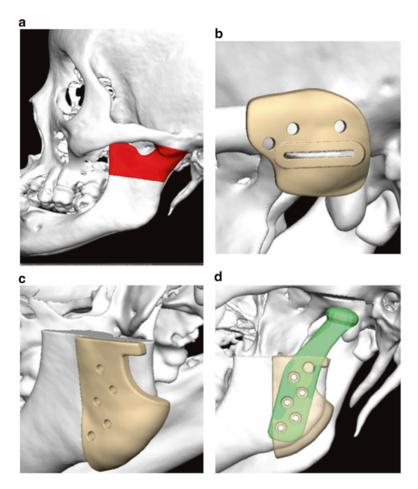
(a) Preoperative CT showing the planned osteotomy. (b,c) Computer-designed cutting guides based on the preoperative plan. (d) Mandibular cutting guide with the stock Biomet prosthesis component positioned. The cutting guide can be used to drill the screw holes prior to implantation. This ensures correct position and orientation (Images courtesy of Dr. Ron Caloss)
